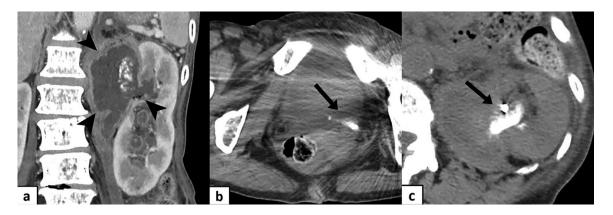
(a) Computed tomography (CT) image 2 months after the cryoablation shows hydronephrosis with perirenal abscess on the left side and (b) high-density debris in the lower part of the left ureter; (c) CT images 2 days after the stent placement shows that the necrotic tumor has moved into the tract of urinary fistula.
